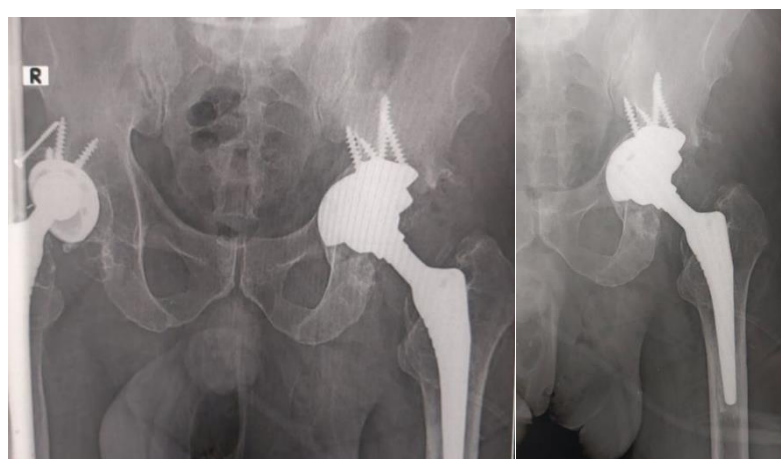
post-operative x-ray showing the TMA and the revised acetabular component.
